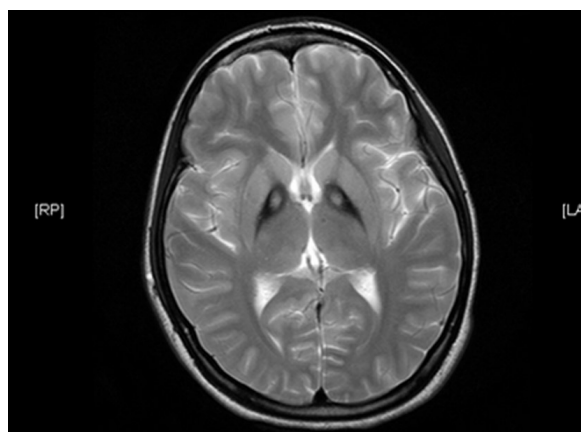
Magnetic resonance imaging of the brain with gadolinium showing bilateral basal ganglia hypodensities with central hyperdensity: the 'eye-of-the-tiger' sign
